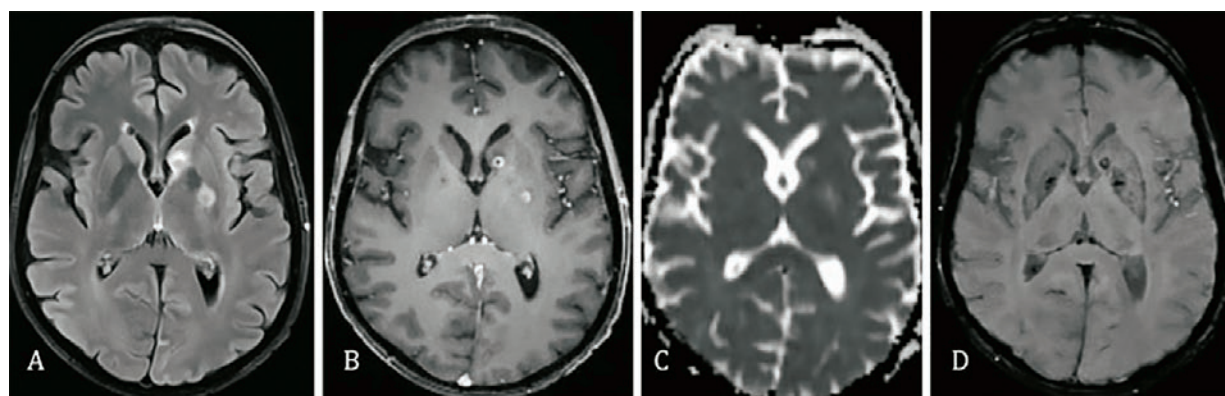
Microabscesses caused by *Candida* on MRI FLAIR, T2 weighted, DWI and SWI images.
